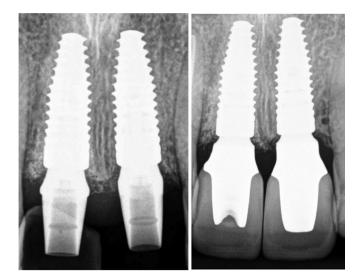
Periapical radiograph taken 6 months (left) after implant placement on site of #9 and 14 months after implant placement on site #8. Bone graft particles are seen coronal to the interproximal bone crests beneath the papillae at both mesial and distal aspects of the implants as well as between the implants. Periapical radiograph at 4 years follow-up (right) showing the maintenance of the residual graft particles coronal to the bone crests, however, if compared to the radiograph on the left, the bone particles/bone crest decreased in height (compared to the level of the implant platforms on both the left and right radiographs) after changing the abutments (see discussion for possible explanation)
